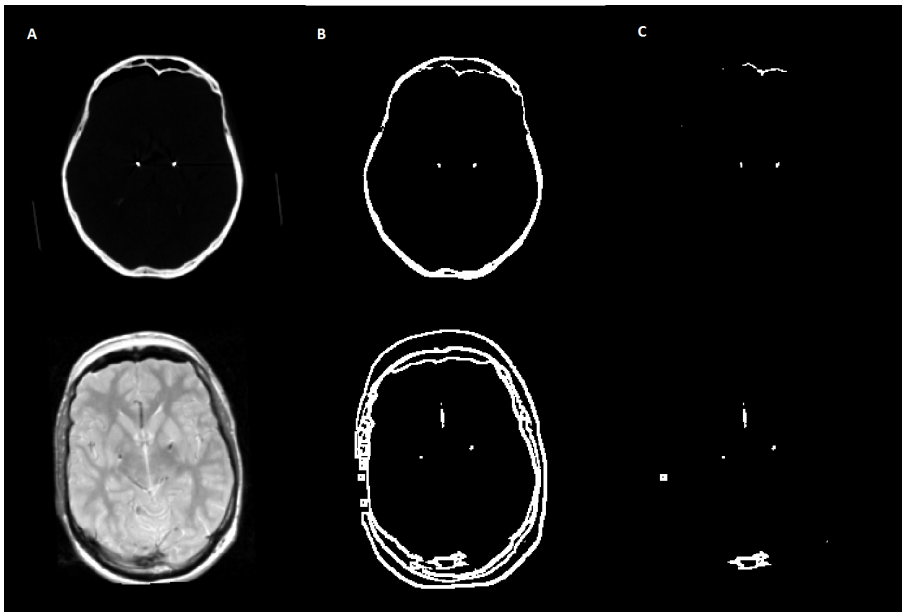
CT (above) and T2-MRI (below) (A) after the enhancement process; (B) after the intensity threshold was applied and, for the case of T2 datasets, after the intensity threshold and the subtraction of the brain mask were performed; (C) after the skull removal, based on solidity and area of the 2D connected components.
